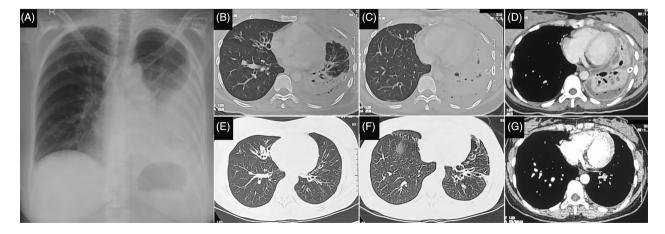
Chest x-ray (CXR) and computed tomography (CT) scan of the female patient in case 1. (A) Initial CXR showing homogeneous opacities consistent with pleural effusion in the lower two-thirds of the left lung. (B–D) Initial CT images showing consolidation with small cavitating lesions in the left lower lobe, along with a chest tube for empyema drainage. (E–G) Follow-up CT images demonstrating radiographic improvement and the presence of bronchiectasis in the middle lobe, lingula, and left lower lobe.
